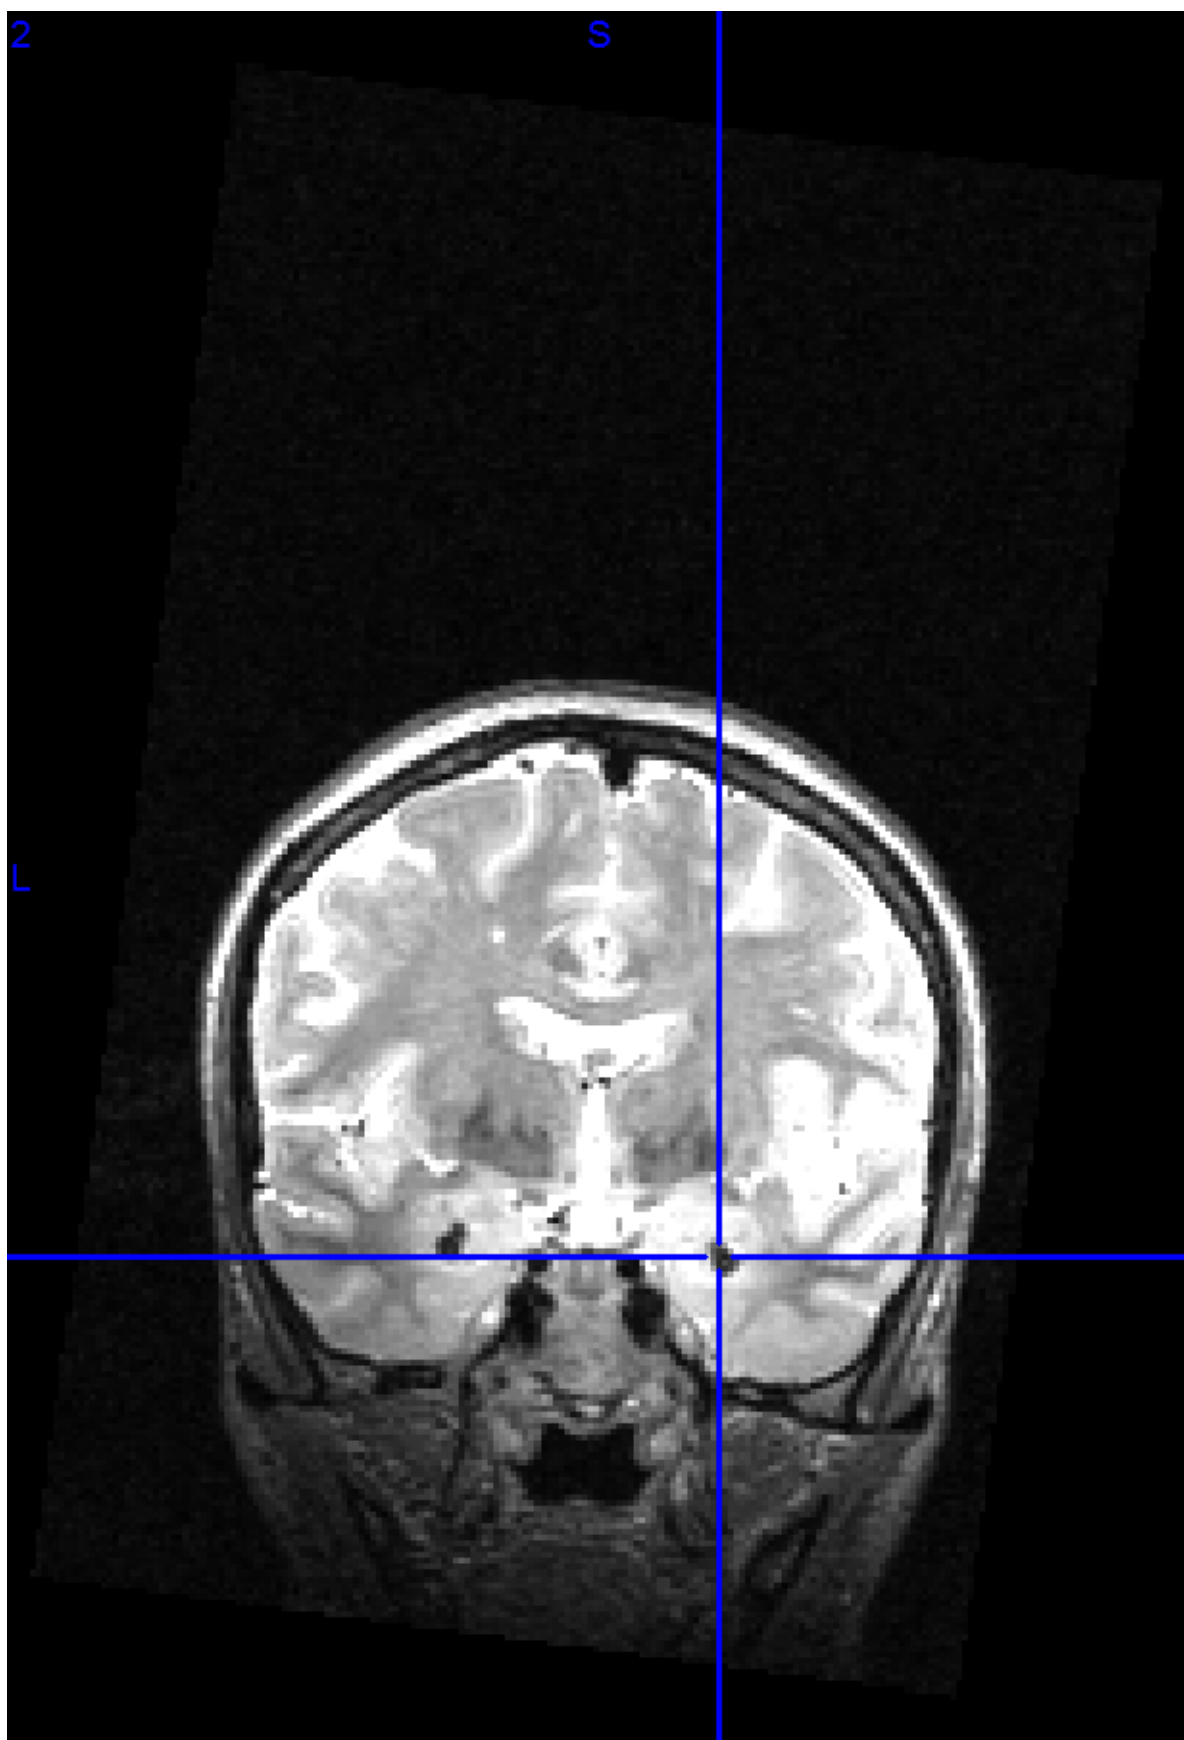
MRI scan for UWD patient no. 1.
